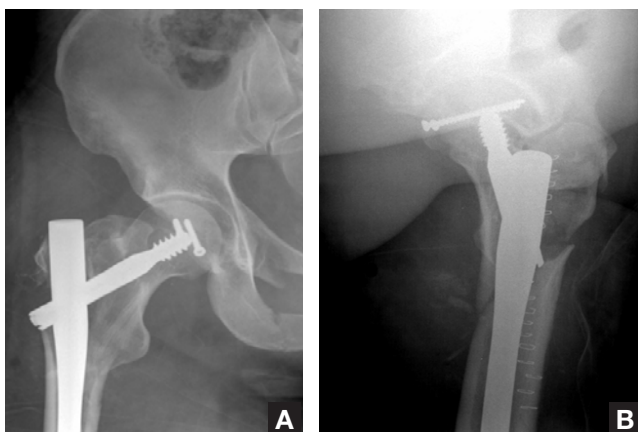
(A) Anteroposterior and (B) lateral postoperative plain films show anatomic reduction of the femoral head fracture with two 4.0-mm screws. The intertrochanteric femur fracture was stabilized with a cephalomedullary nail.
